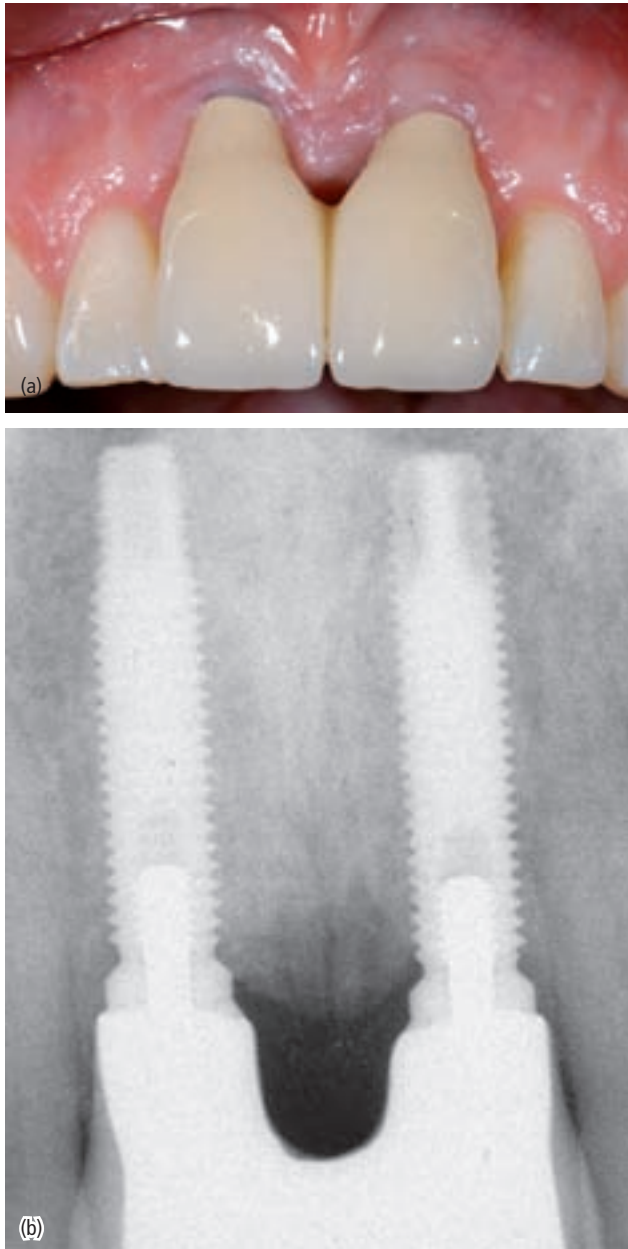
(a) Severe esthetic complication with a recession of the facial mucosa at implants 8 and 9, which were placed as immediate implants after extraction. Both implants were inserted too deep into an apical malposition. As a result, both implant crowns are too long owing to the mucosal recession. In addition, the interimplant papilla is clearly reduced. (b) The periapical radiograph confirms the apical malposition and the horizontal bone resorption between both implants. Both are the main causes of the esthetic complication.
